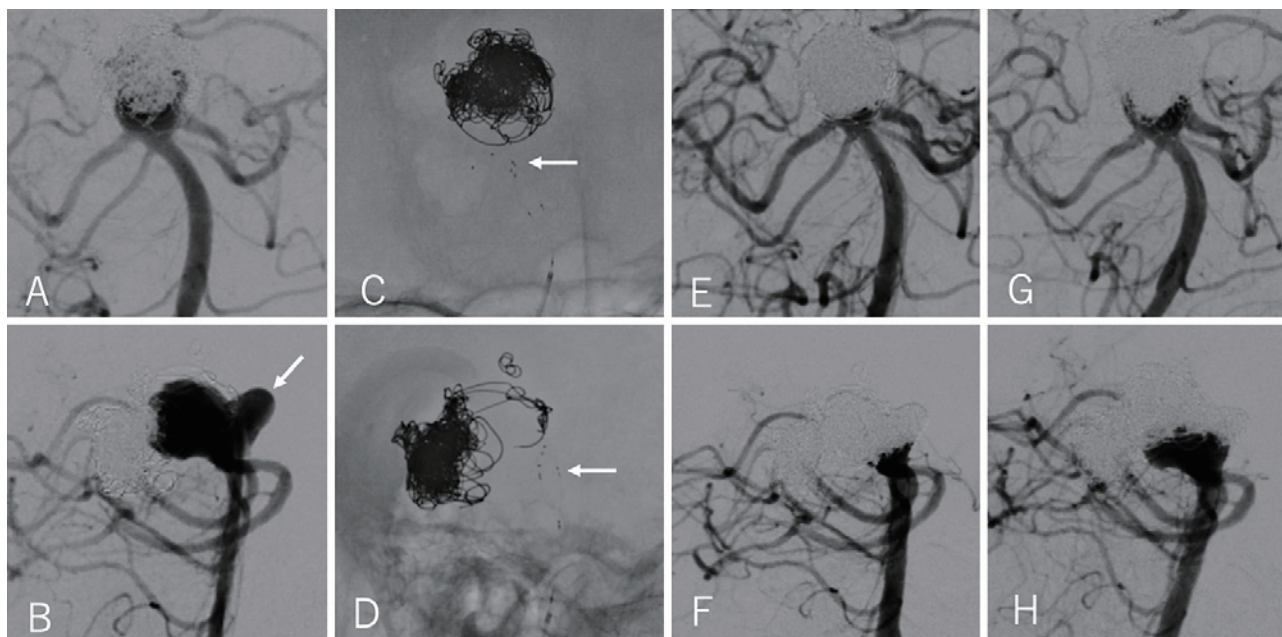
Pre- and postoperative findings of PulseRider-assisted coil embolization and stent-assisted coil embolization 16 years after initial treatment. The anterior view (A) and lateral view (B) of digital subtraction angiography (DSA) show the recanalization of the basilar tip aneurysm with an anterior bleb (white arrow). The anterior view (C) and lateral view (D) of the X-ray photograph show the deployed T-shaped PulseRider (white arrow). The anterior view (E) and lateral view (F) of DSA demonstrate appropriate aneurysm obliteration after PulseRider-assisted coil embolization. The anterior view (G) and lateral view (H) of DSA show the recanalization of the basilar tip aneurysm at 6-month follow-up of PulseRider-assisted coil embolization.
